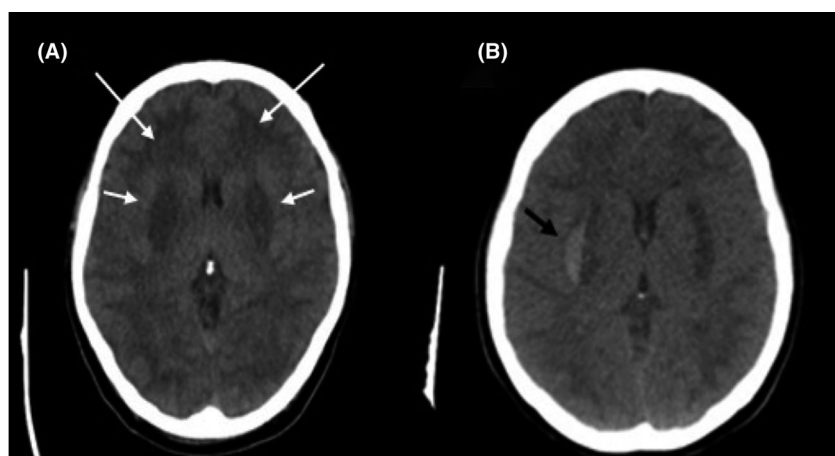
Brain computed tomography scans in two patients with methanol poisoning. A, Bilateral putaminal (short white arrows) and white matter hypodensity (long white arrows). B, Bilateral putaminal hypodensities accompanied by right-lateral hemorrhage (black arrow).
